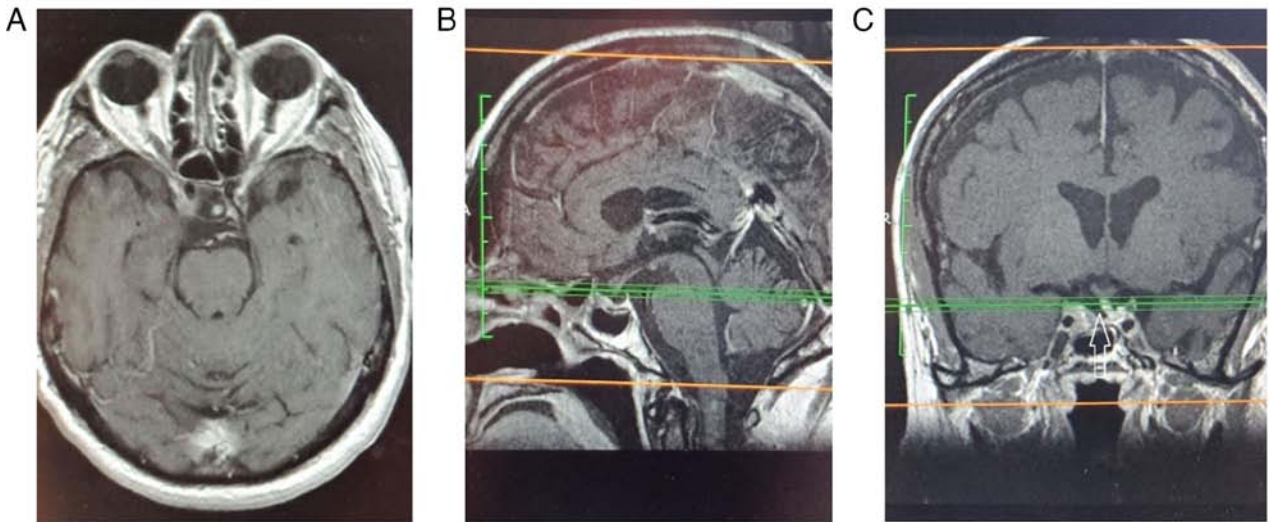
(A-C) Post-operative contrast enhanced T1 MRI scan of patient 5, following the endonasal endoscopic gross total removal of the macroadenoma. Note the pituitary stalk that is free of pressure (arrow).
